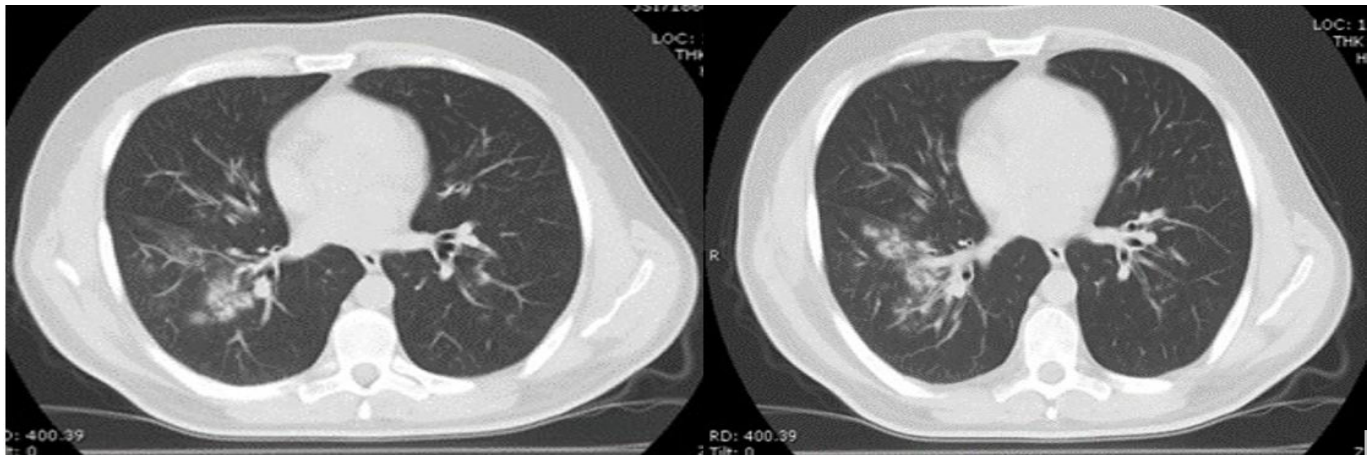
Chest computed tomography showed mild patchy ground-glass density increases in the right lung upper lobe and middle lobe. And reticulonodular infiltration at the right lung lower lobe hilar level and laterally
